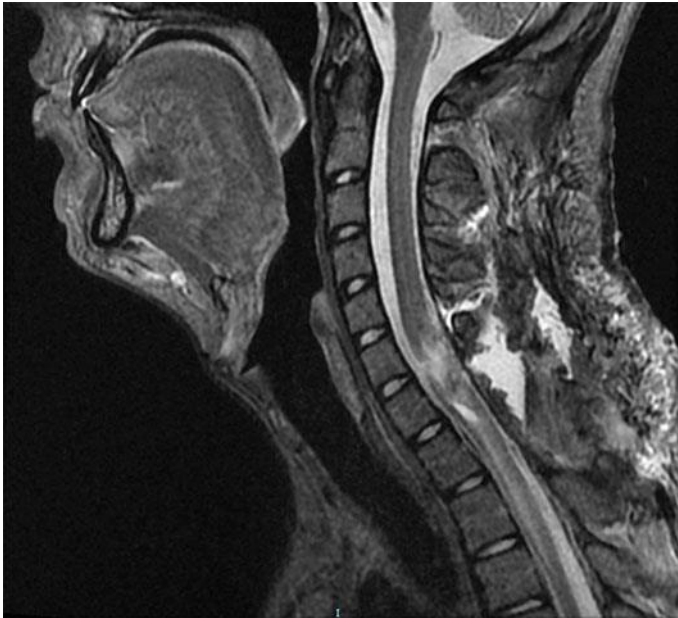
Postoperative T1-gadolinium MRI showing removal of IS.
